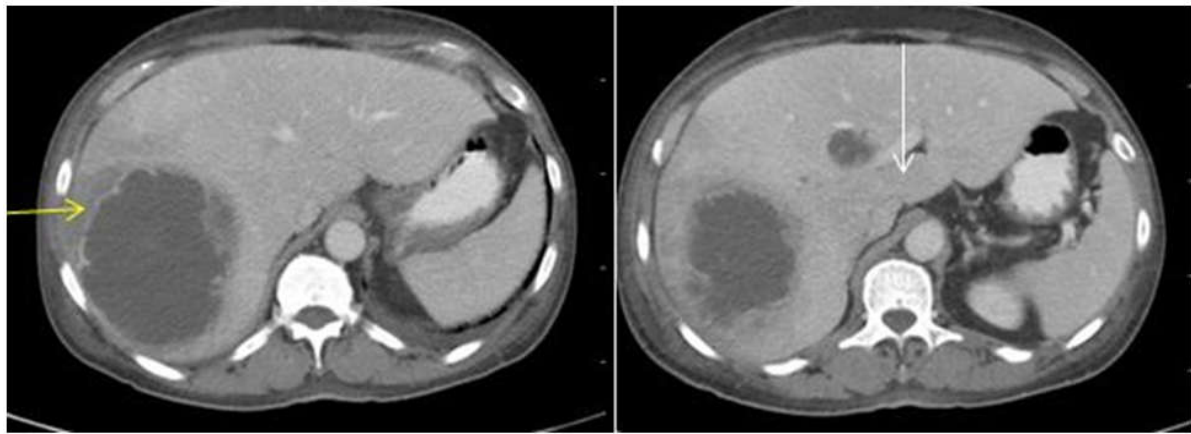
CT Abdomen (plain) axial shows evidence of well-defined multilocular, hypodense abscess in the right hepatic lobe (segment VII and VIII) and in the medial segment of the left lobe (IV b)
